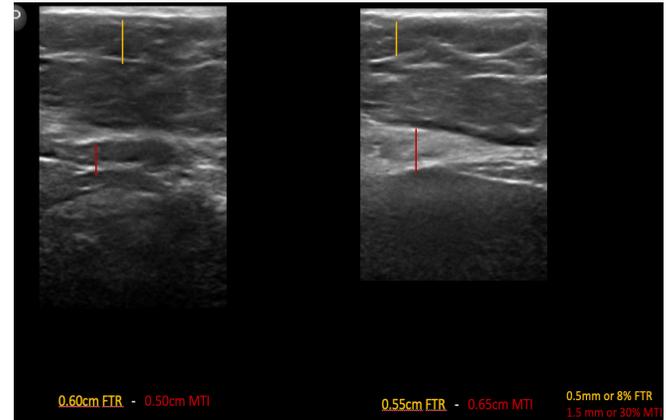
This is a 54-year-old Caucasian female who received six treatments on her abdomen and flank. The left ultrasound shows baseline and the right ultrasound shows results after 4 weeks follow up of the treated abdomen. At 12 weeks follow-up, she had a 30% Muscle Thickness Increment and 8% Fat Thickness Reduction.
